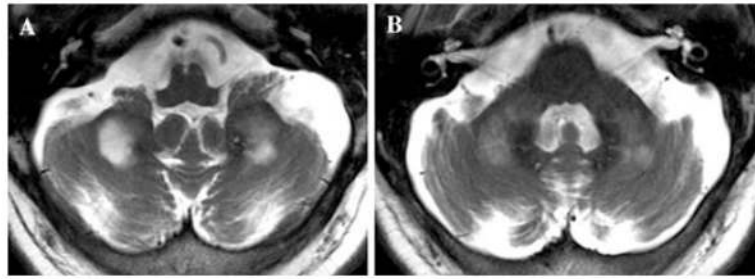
MRI features of fragile X-associated tremor ataxia syndrome (FXTAS). White matter pallor is seen in the cerebellar parenchyma (A), as well as in the middle cerebellar peduncles (B).
